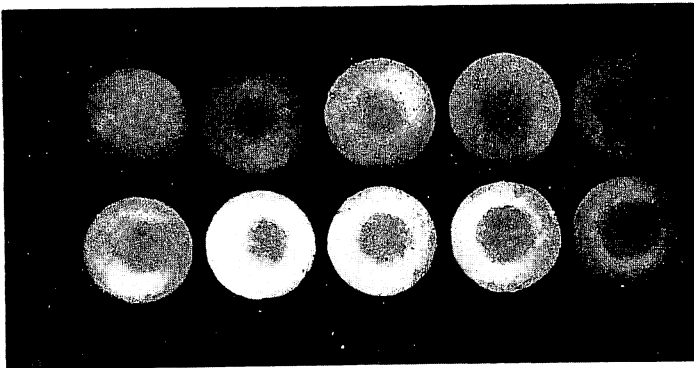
Rotatory Cross Section Radiogram (top) and tomogram (bottom) of a beeswax cavity encircled with thick wall, showing no distortion (top) and distortion (bottom) of X-ray image
